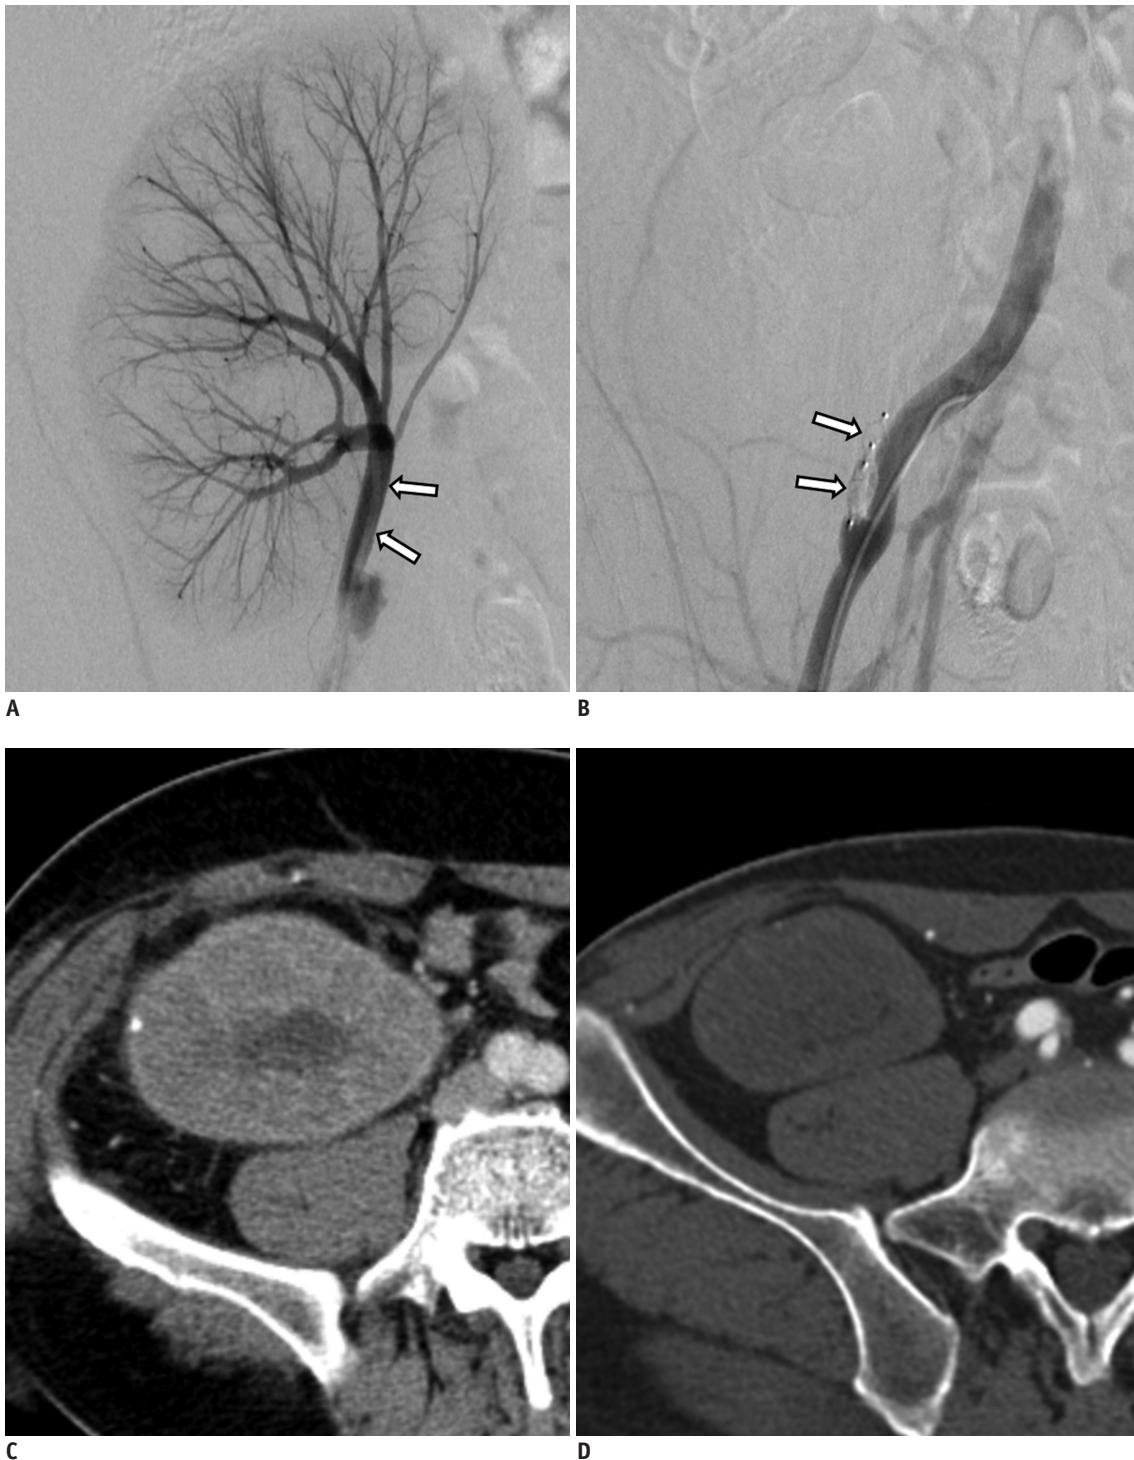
49-year-old male patient (No. 4) with chronic transplanted kidney rejection presenting with hematuria and pain. A. Arteriogram of graft renal artery (arrows) arising from right external iliac artery shows normal angiogram without bleeding focus. B. Arteriogram obtained following embolization reveals successful occlusion of graft renal artery using two vascular plugs (arrows), gelfoam pledgets and NBCA. C, D. CT scans obtained before (C) and six months after (D) embolization show decrease in size of graft kidney. There was no residual renal enhancement seen on six-month follow-up CT scan.
